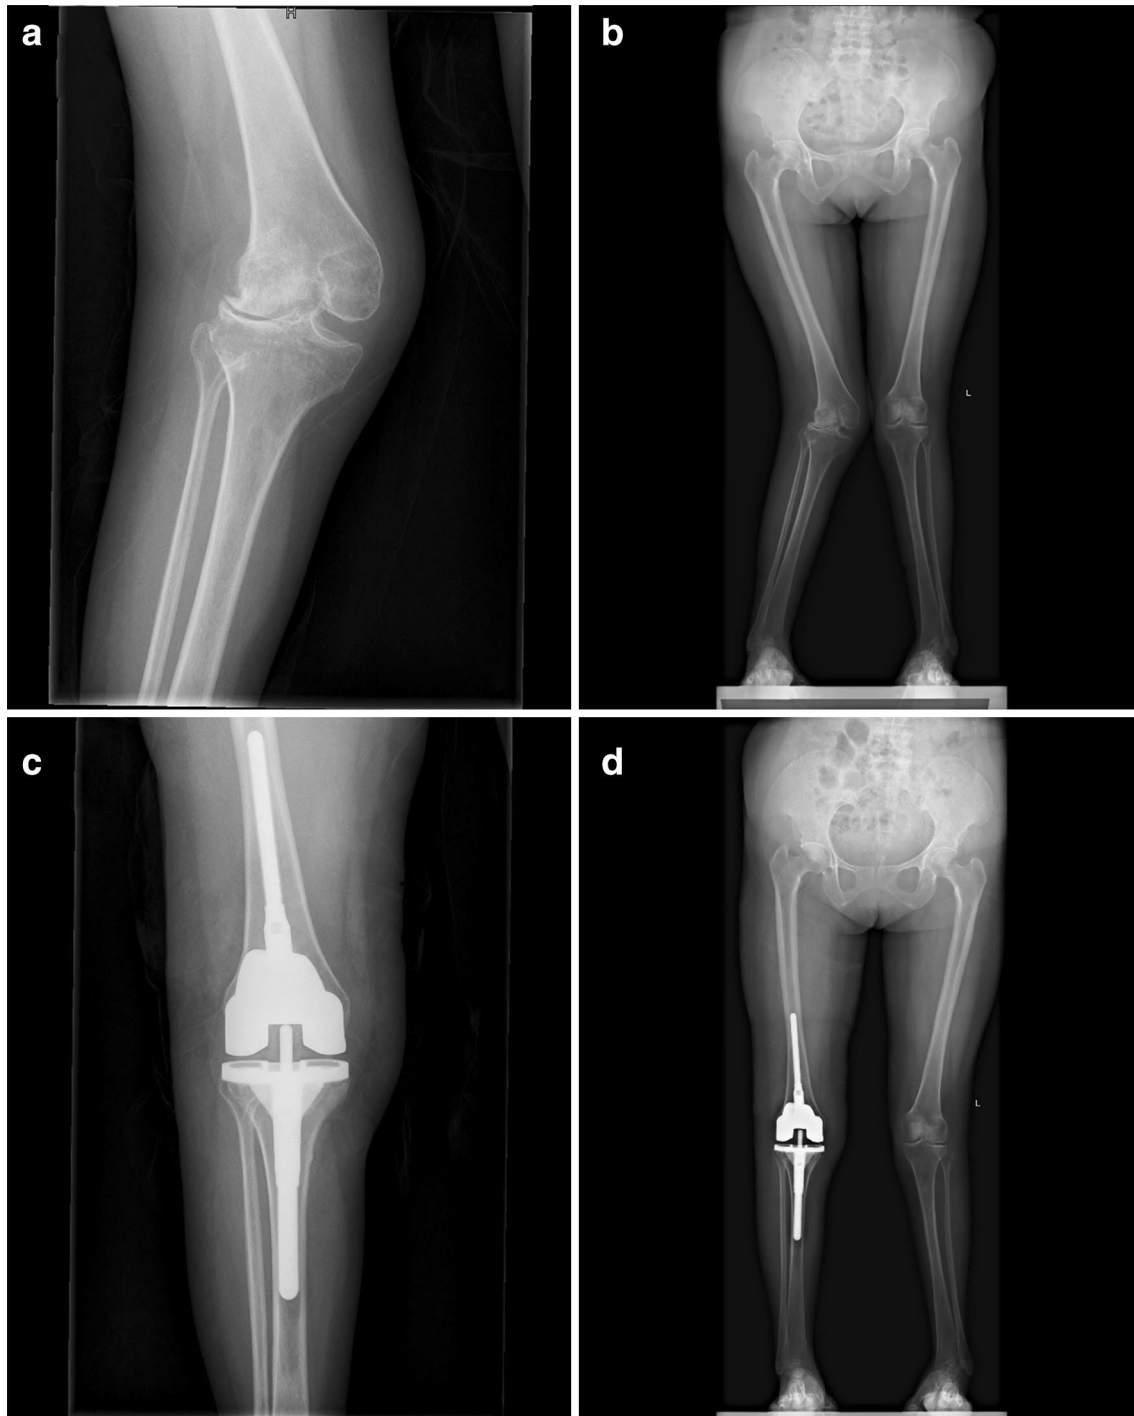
The radiographs of a 62-year-old woman treated by medial femoral epicondyle upsliding osteotomy. a Anteroposterior preoperative knee radiograph showing severe valgus deformity. b Preoperative standing radiograph of both lower limbs showing valgus angle more
